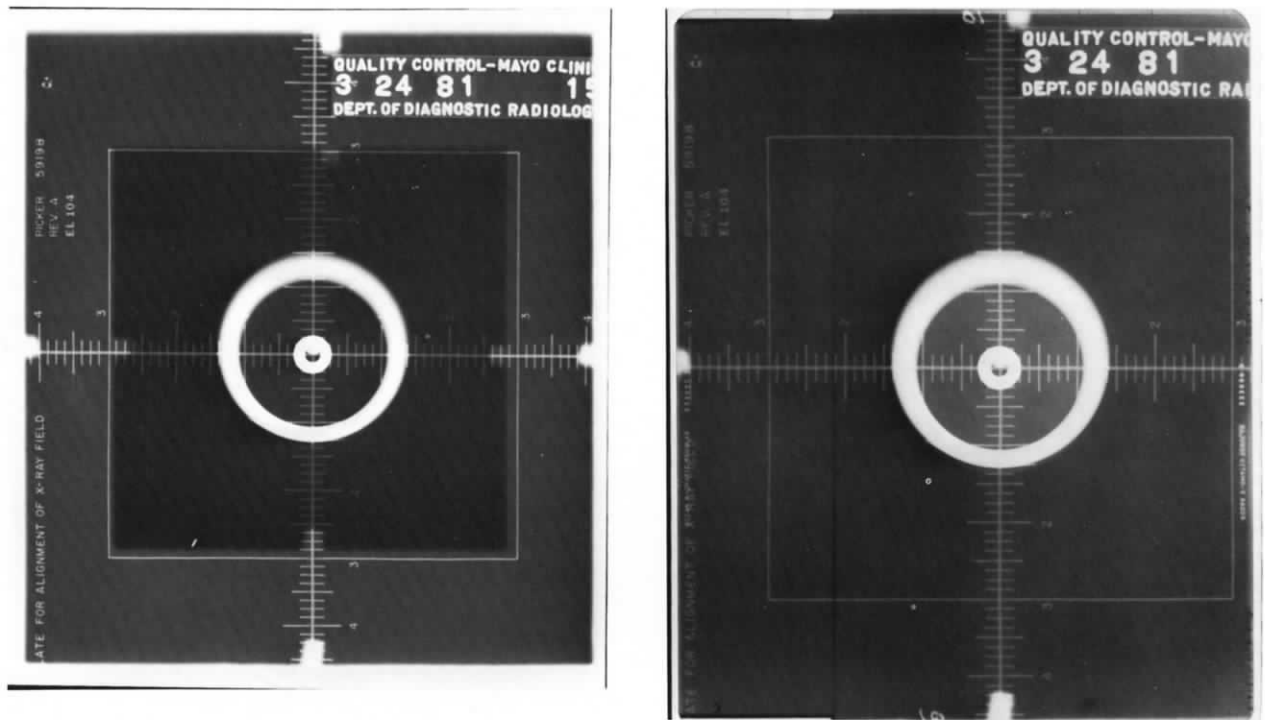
This would be an acceptable result except that the x-ray beam perpendicularity exceeds acceptance limits. Left film from tabletop; right film from Bucky tray.
